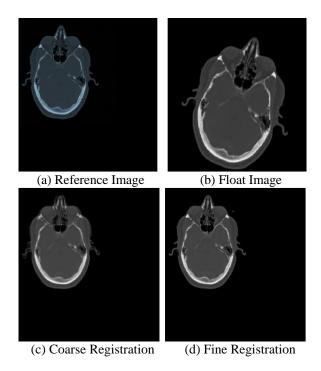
Registration between CT Images for downscaling
